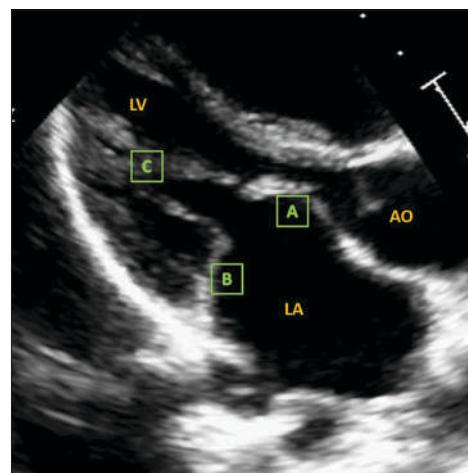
Parasternal long-axis view of the heart. All morphological features of rheumatic mitral stenosis are present as per the World Heart Federation criteria^[3] (A: Thickened anterior mitral leaflet, B: Thickened and fixed posterior mitral leaflet, and C: Chordal thickening). LA: Left atrium, LV: Left ventricle
